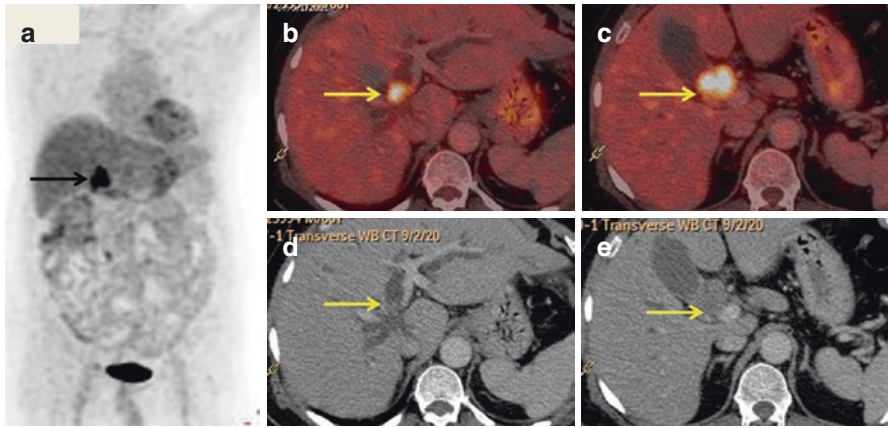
^{18}F -FDG PET/CT study of a 61-year-old male, diagnosed case of hilar cholangiocarcinoma. The study shows hypermetabolic mass at the confluence of right and left hepatic ducts (*arrow* in a–e) (maxSUV 13.51) with bilateral IHBR dilatation
